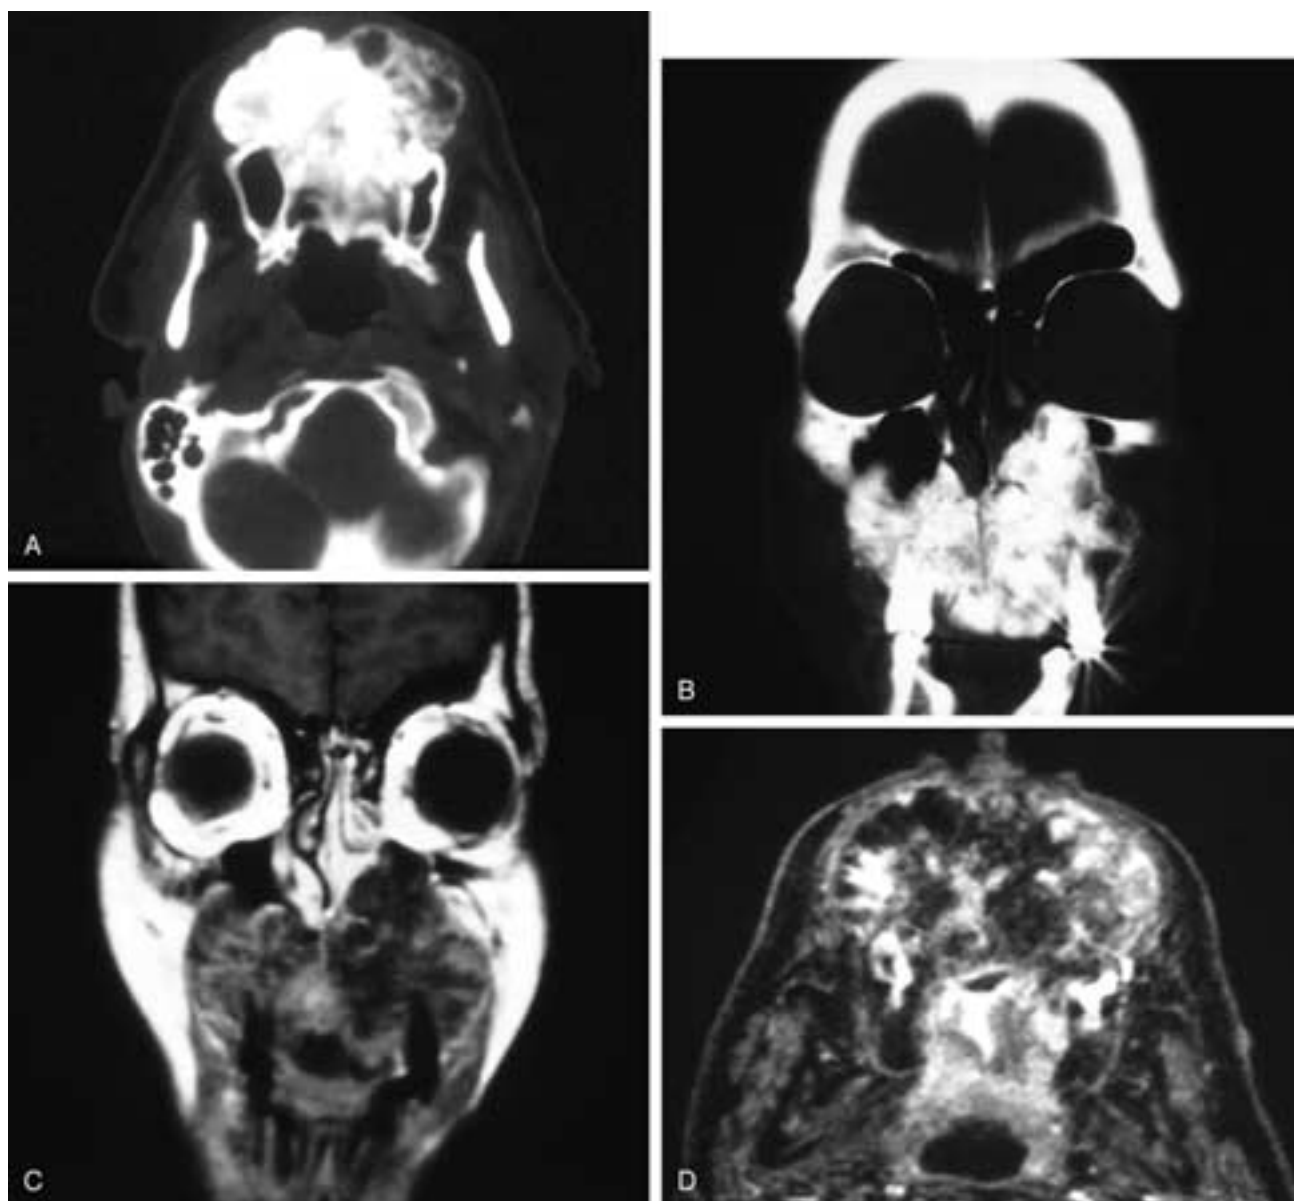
Axial (A) and coronal (B) CT scans show a dense area of bony production in the hard palate. No intact cortex is identified in the region of the mass. Coronal T1-weighted (C) and axial T2-weighted (D) MR images show that this mass is quite nonhomogeneous. The areas of dense bone seen on the CT scan are for the most part of low signal intensity, but the lesion is not as clearly separated from the adjacent uninvolved maxilla and maxillary sinuses as it is on the CT scan. This patient had an osteogenic sarcoma.
